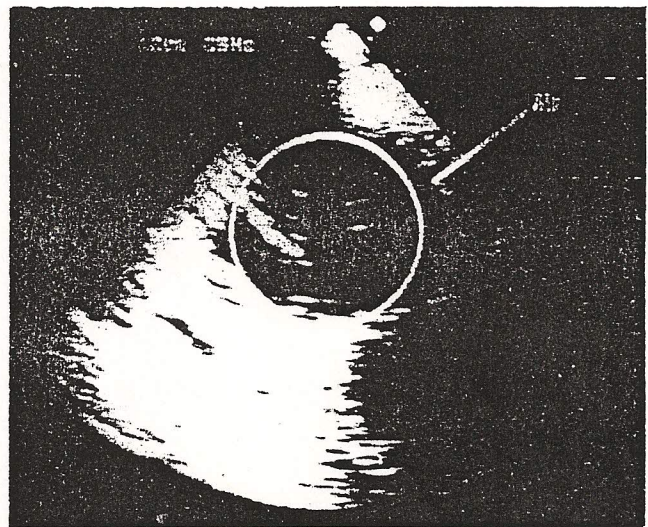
Transoesophageal echocardiography deairing progression to be accurately assessed. The metallic large-bore needle used to vent the left ventricle is visible
